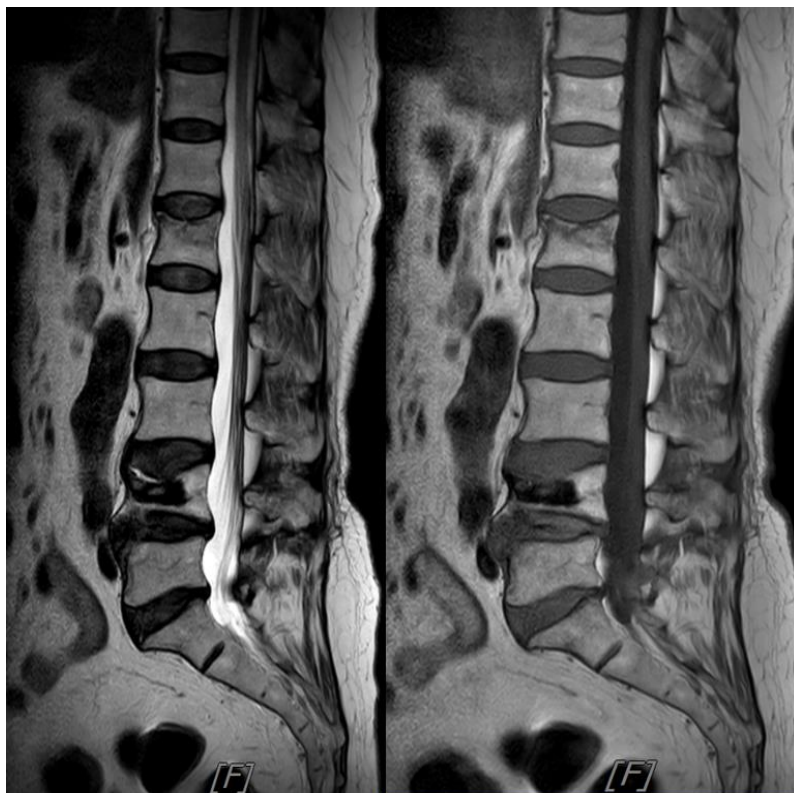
L-spine MRI images taken at another facility. Parasagittal T2 & T1-weighted images show acute L1 vertebral body compression fracture
